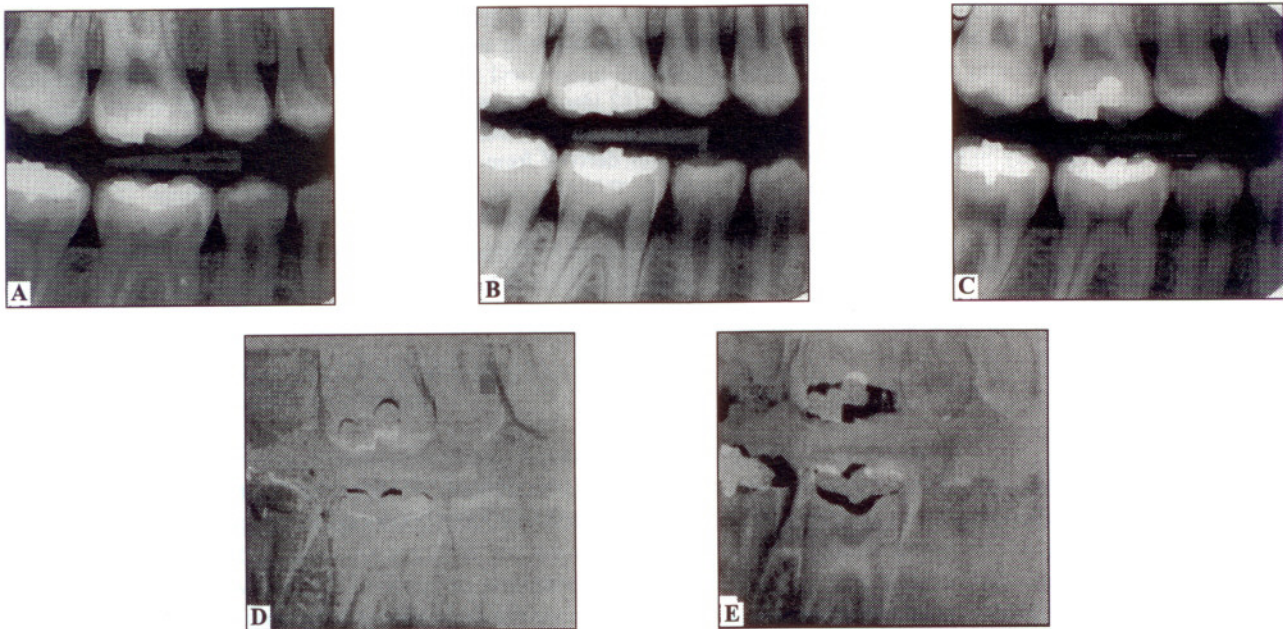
Radiographs from the same (a+c) and two different (b+c) individuals with fillings and the resulting subtraction images [d(ac) and e(bc)].
